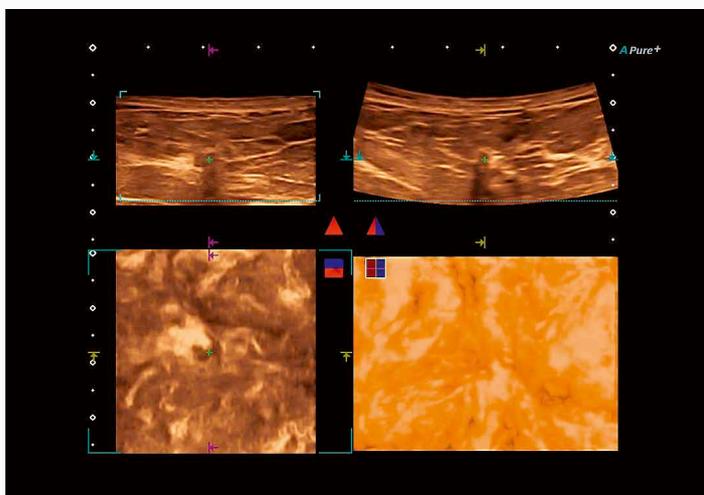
Volume sonography and 3D visualization of the lesion. In the frontal plane note irregular delineation and retraction which are both malignancy criteria.
